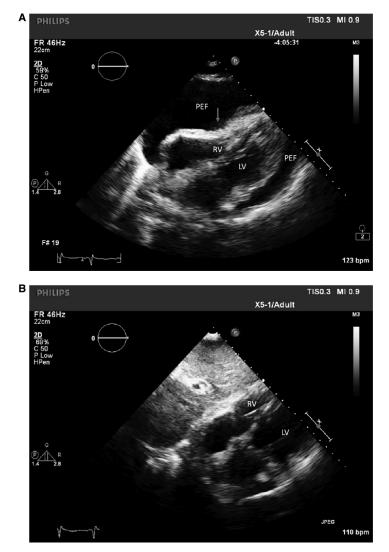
A*, 2-D echocardiography subcostal view showing pericardial tamponade with diastolic compression of the right ventricle (*RV*) from a large pericardial effusion (*PEF*). B, 2-D echocardiography subcostal view after pericardial drain placement showing resolution of PEF and expansion of RV. *LV*, left ventricle. Image courtesy of Michael C. Reed, MD.
